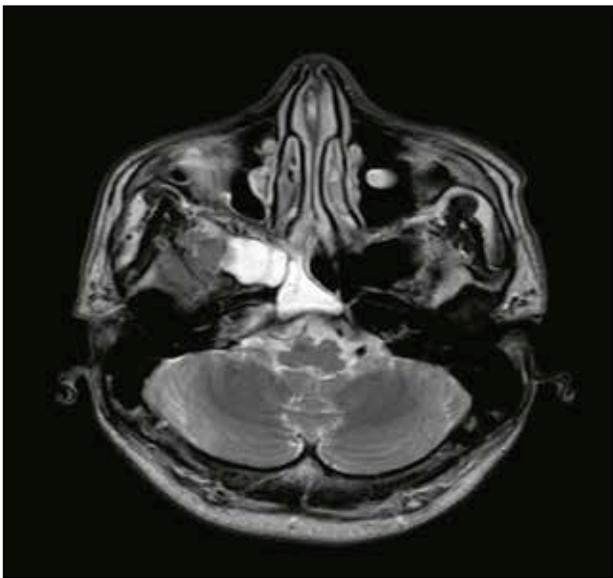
Cranio-facial MRI, axial (A) and coronal (B) section: opacification of the right sphenoid sinus due to the fluid content and the inflamed mucosa.
